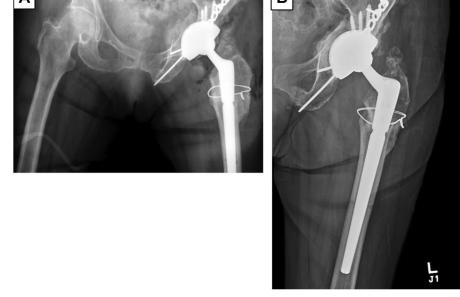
(A) Immediate postoperative radiographs after revision of the acetabular component. (B) Six-month postoperative AP left hip radiograph demonstrating healing bridged callus along the posterior column and maintained alignment of the acetabular component.
